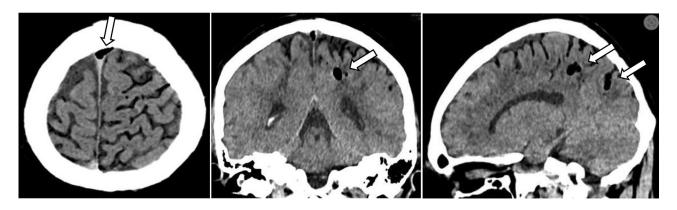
Noncontrast enhanced CT axial, coronal, and sagittal images of the head demonstrating air in the superior sagittal sinus and in the left frontoparietal subarachnoid spaces, as demonstrated by the white arrows.
